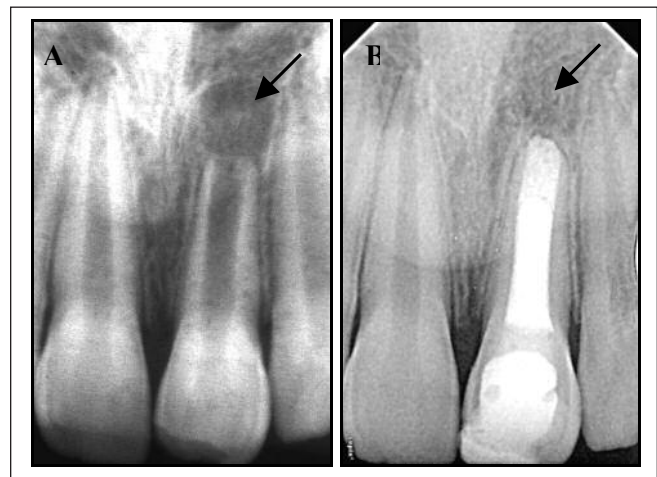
Radiographic pictures showing the healing of periapical radiolucent lesion. A. Preoperative B. 12 month follow up
